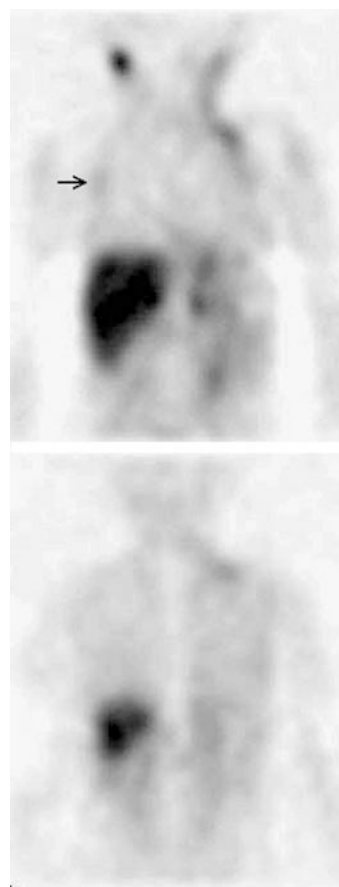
Two single photon emission tomography (SPECT) coronal sections again demonstrate absent uptake in most of neck and posterior thorax. A small amount of uptake is noted in the right lateral chest (arrow) corresponding to brown adipose tissue uptake present more extensively on the left
